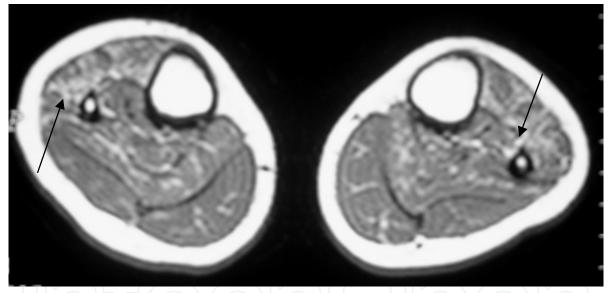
b - Case III-1. mMRI, T1-weighted images and axial sections showing fatty infiltration of muscle compartments of the anterior, posterior deep and superficial leg with less alteration of the superficial posterior compartment. Note the symmetry condition.
